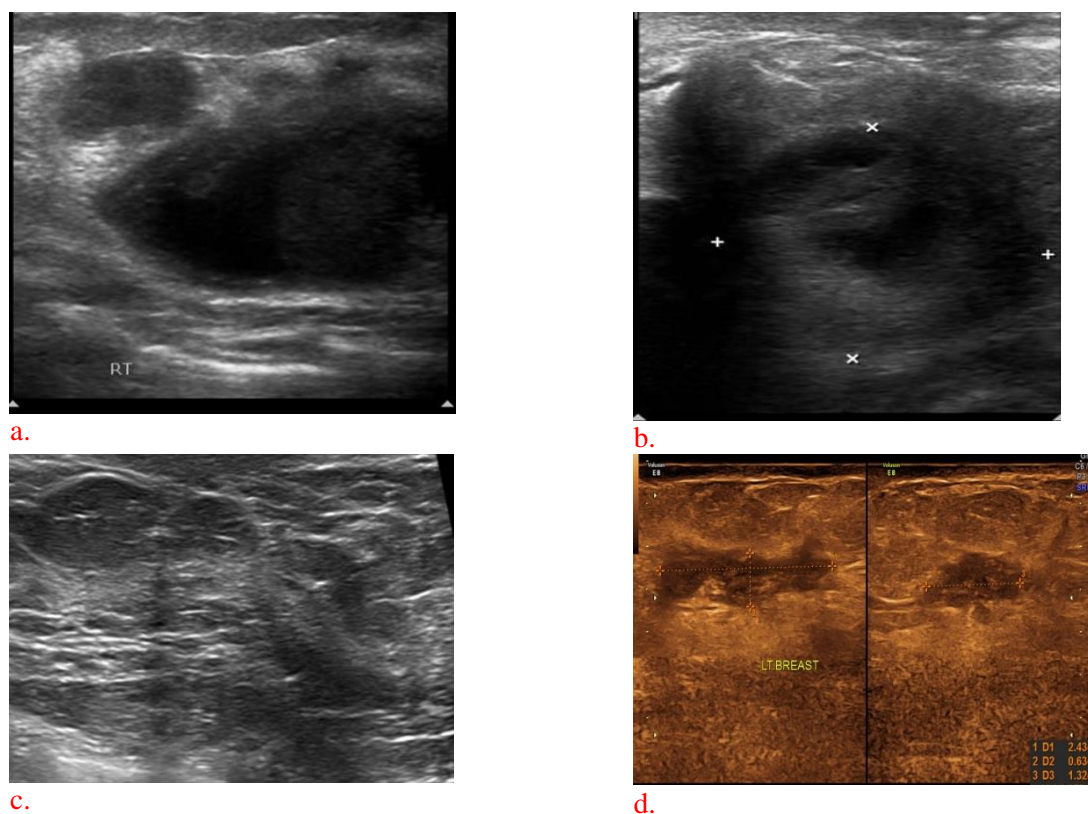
Ultrasound image of breast abscess of four (a-d) patients at time of diagnosis.
